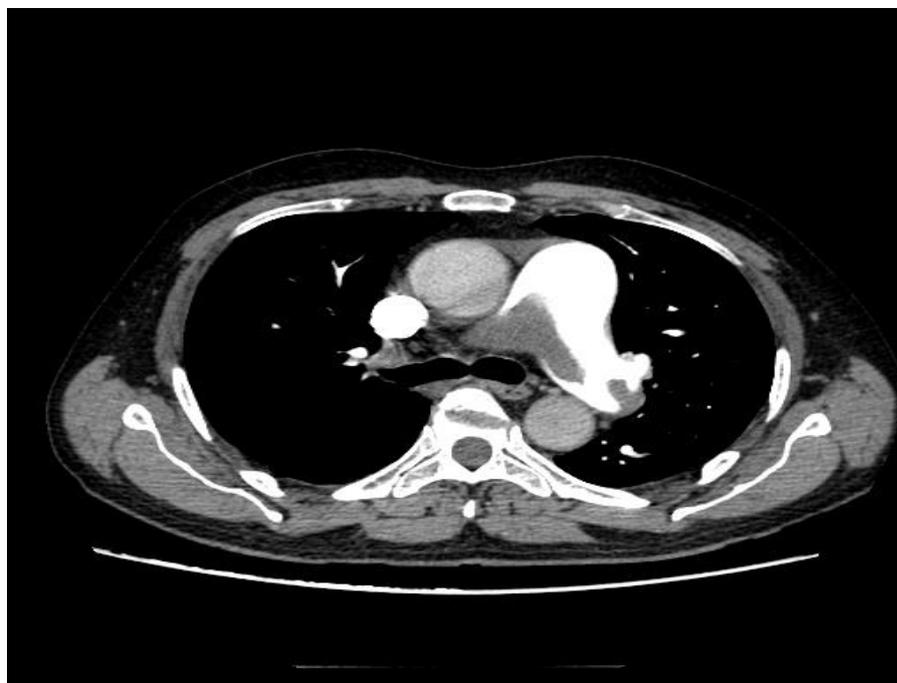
A CT pulmonary angiogram showing the saddle thrombus.
